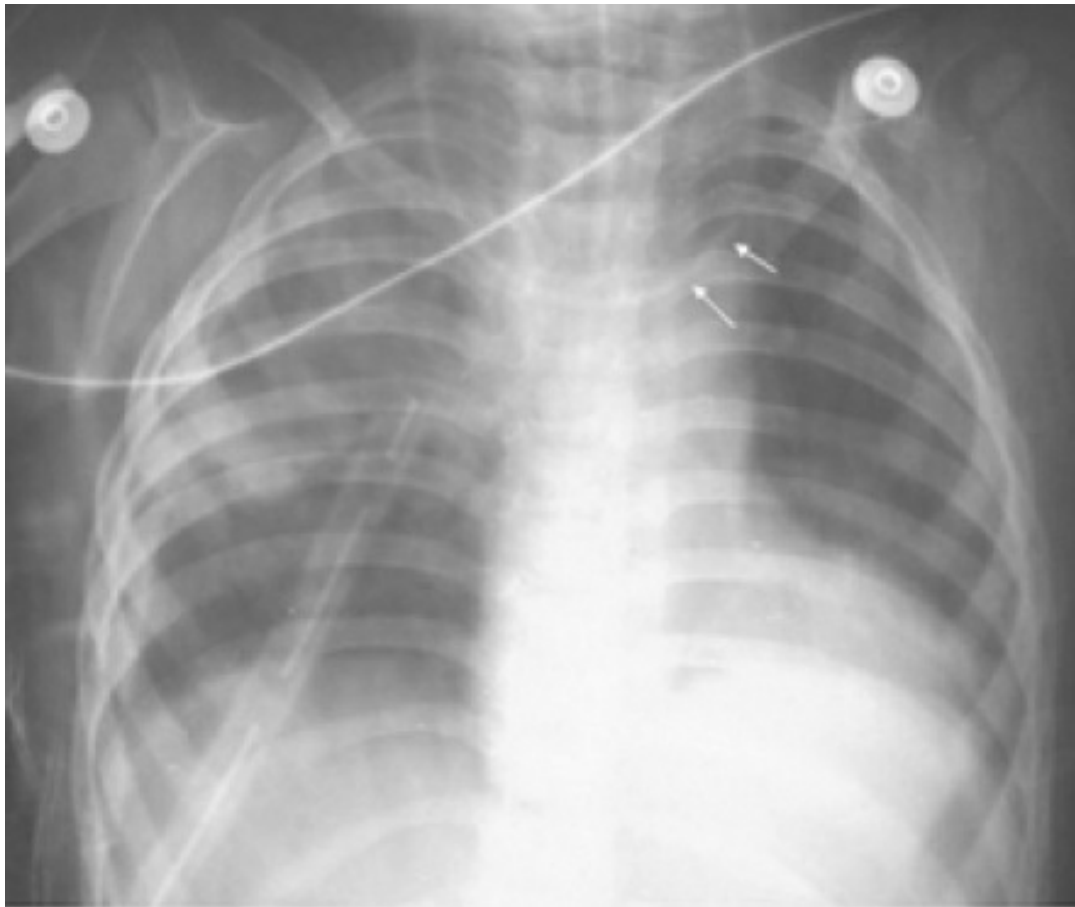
X-ray chest showing malposition of the central venous catheter that was inserted in the right external jugular vein. Note that the catheter has gone to the left side via innominate vein (arrows).
